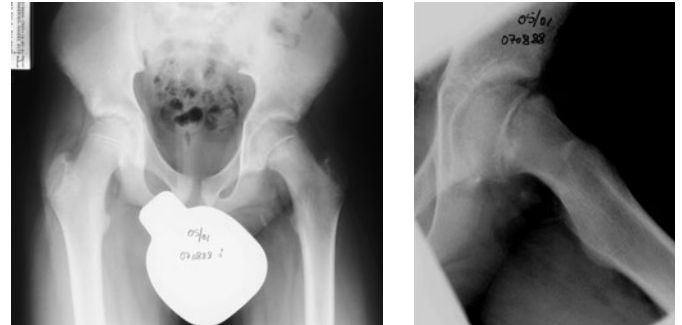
Legg-Calvé-Perthes disease, Herring type C. Avascular necrosis right hip. Anteroposterior radiograph and frog-leg projection of pelvis.
